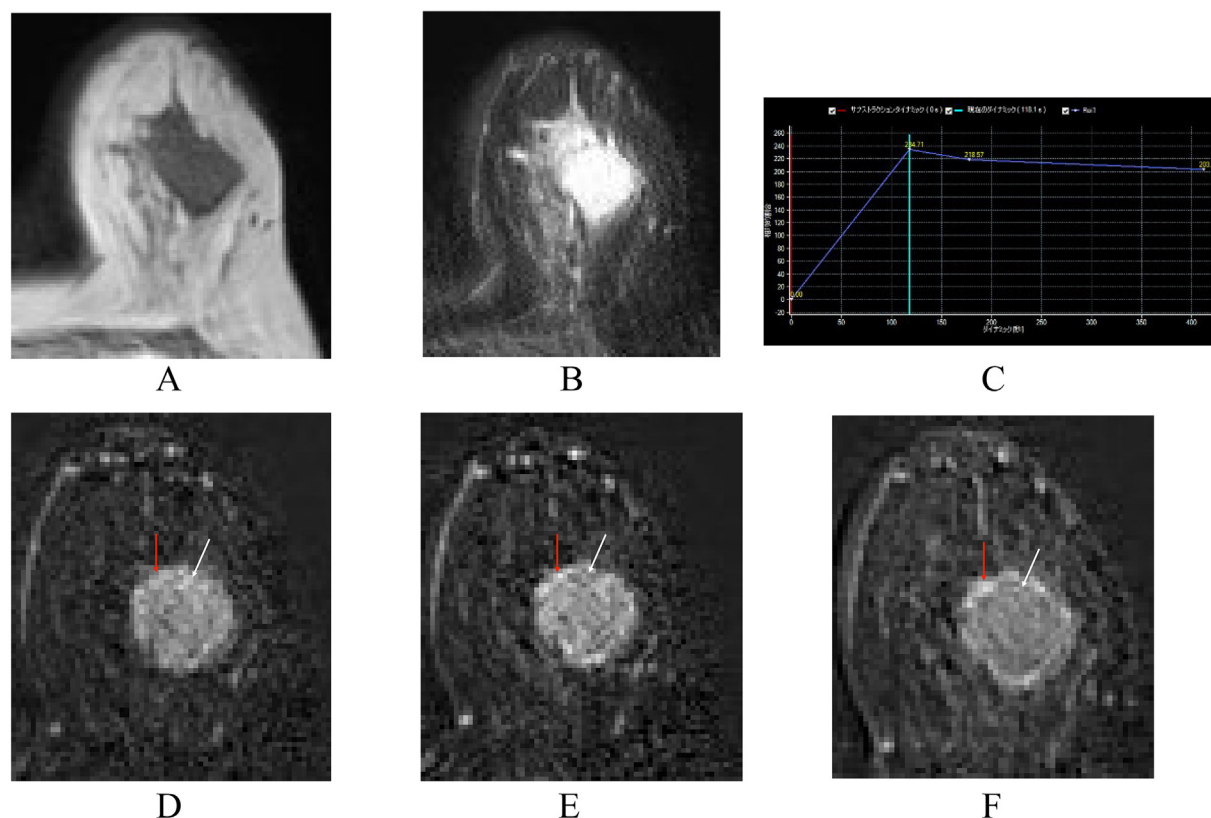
Magnetic resonance image (MRI) findings. T1- (A) and T2-weighted images (B) showed that the tumor did not contain, at least, many fibrous components. The time signal intensity curve showed a fast and plateau enhancement pattern (C). Of the subtraction MRI images, white and red arrows showed the areas showing a wash out pattern and those showing a persistent pattern, respectively (D-F).
